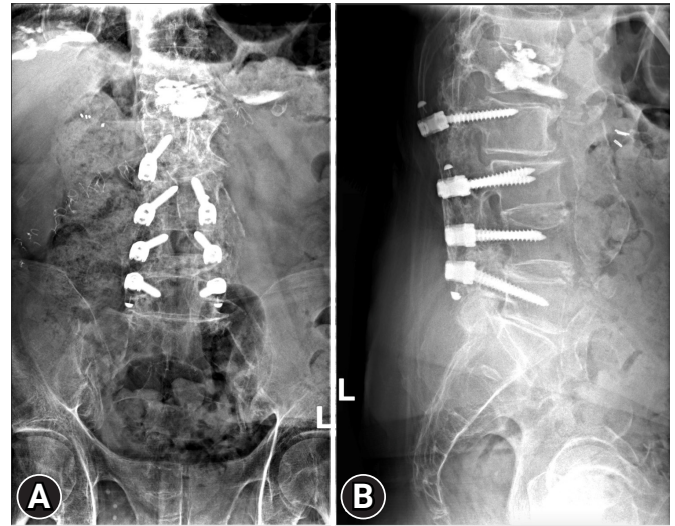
Preoperative x-ray showing prior L2–5 fusion with L1 intravertebral cement anteroposterior (A) and lateral views (B) in an 80-year-old male patient with L5–S1 spondylolysis and symptomatic adjacent segment disease.
